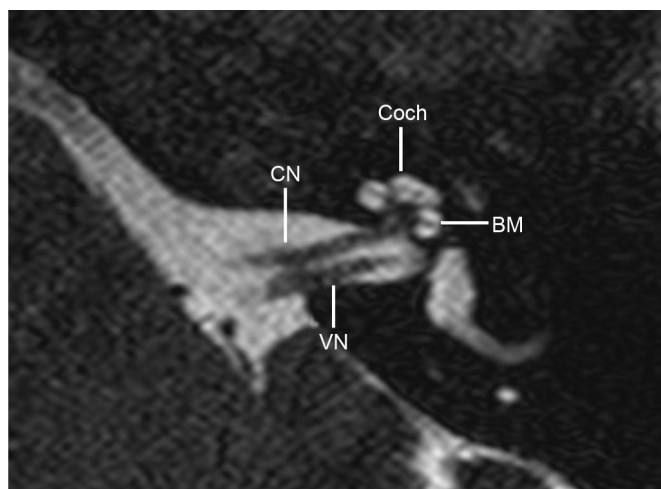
Normal cochlear anatomy. Axial FIESTA weighted MRI scan demonstrating the normal appearance of the cochlear fluid spaces and internal auditory canal. (Coch: Cochlea; CN: Cochlear nerve; VN: Vestibular nerve; BM: Basilar membrane).
